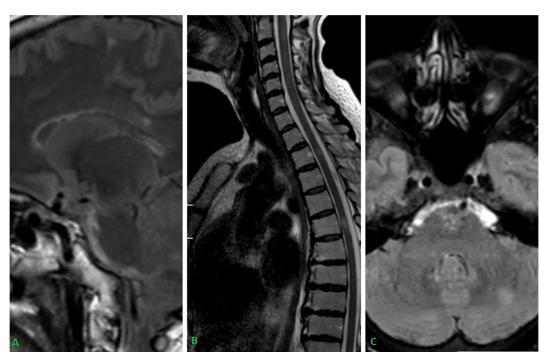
Brain MRI transversalT2-weighted shows hyperintense lesions in the left cerebellar hemisphere, in paracallosalareas and numerous spinal cord lesions.
